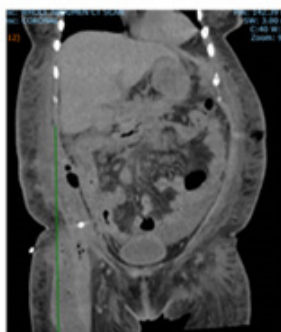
Whole abdominal CT scan coronal view showing extension of WON to the anterior compartment of the right thigh
